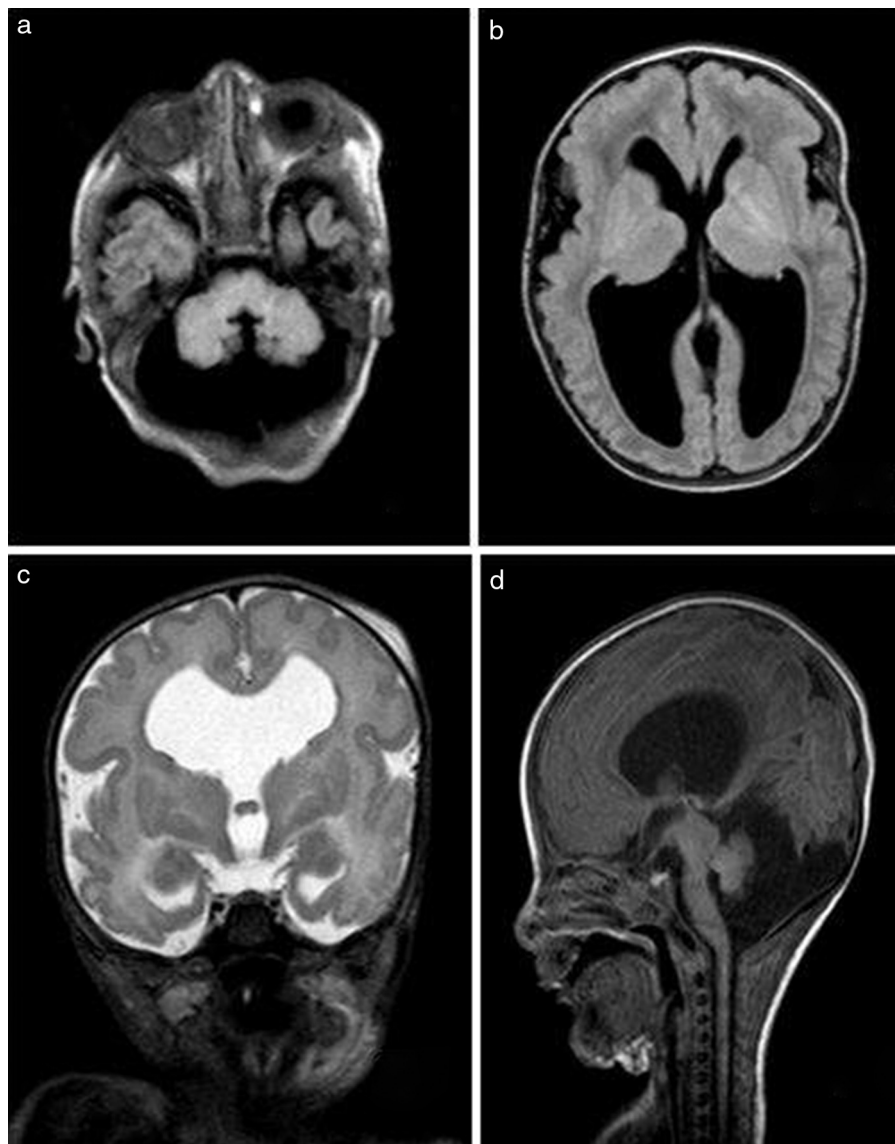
FLAIR MR scan images demonstrating Dandy–Walker abnormality (A and D); and lissencephaly with hydrocephalus (B). T2 WI MR scan image demonstrating septum pellucidum dysgenesis (C).
